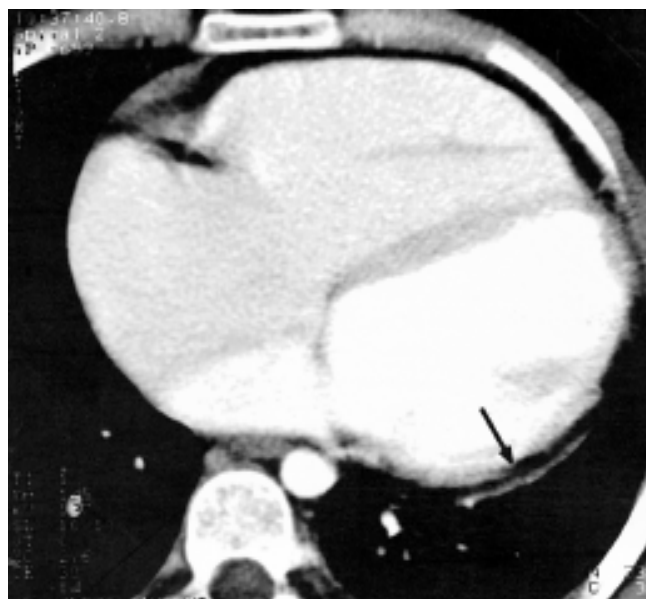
CT scans showed fatty infiltration in the myocardium of the left ventricle wall and also showed that the thickness of the left ventricle wall was 2 mm.
